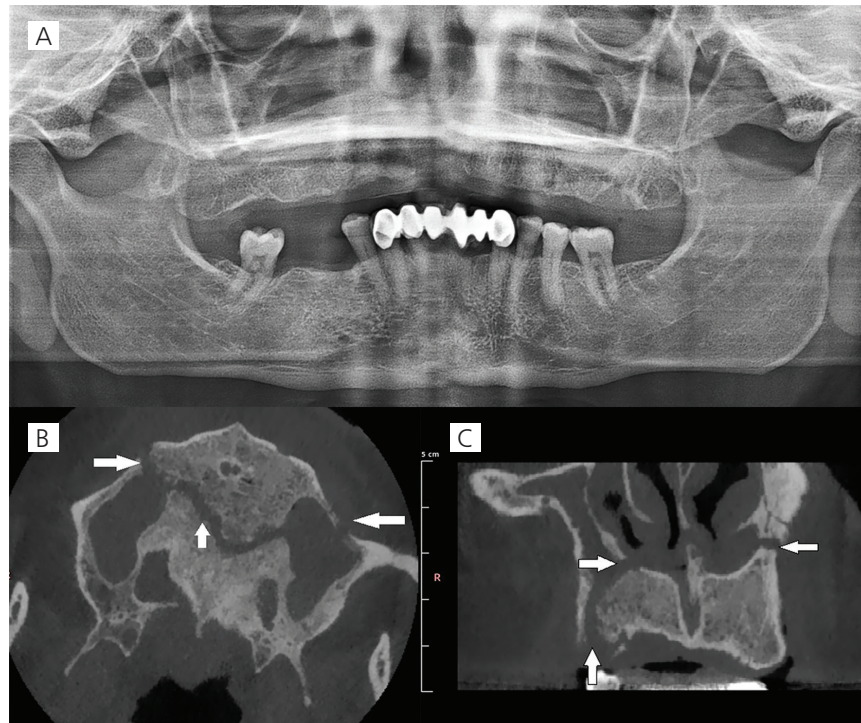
Radiological presentation of Case 2, A) Preoperative orthopantomography, B) DVT axial section, C) DVT sagittal section
